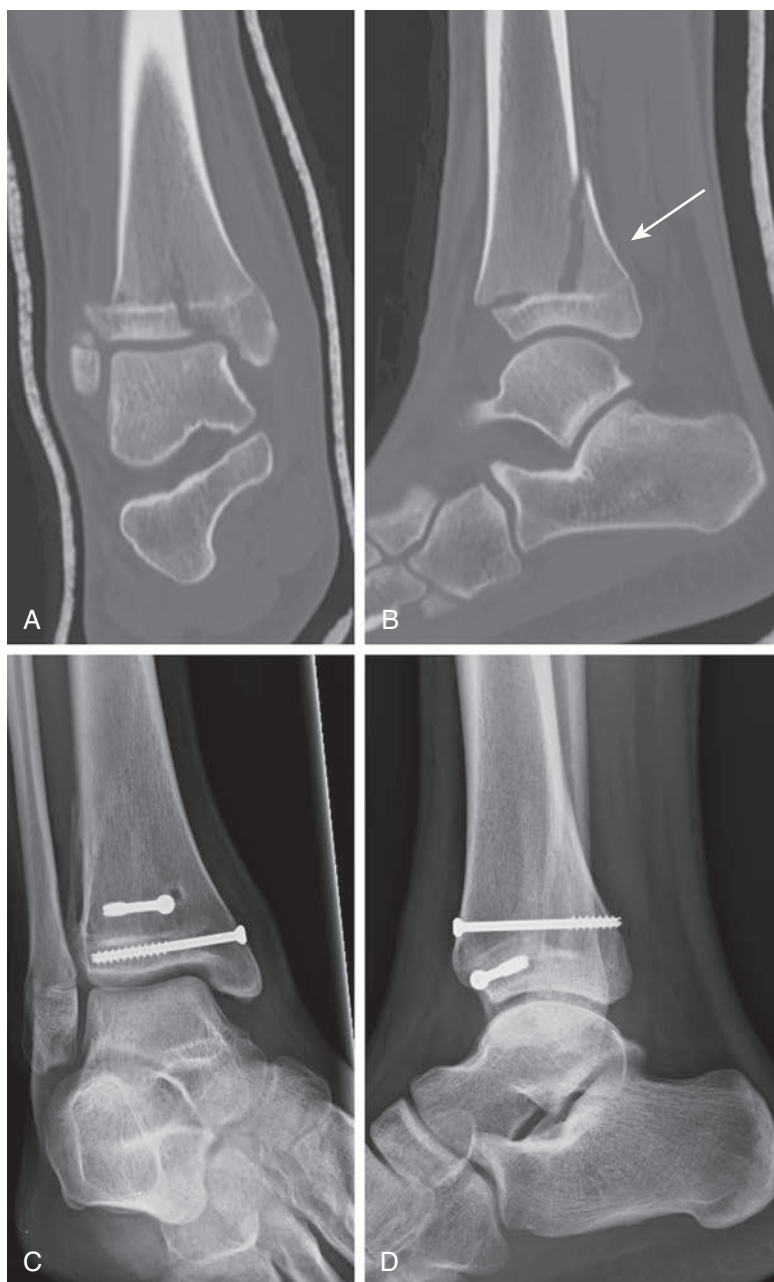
(A) Coronal and (B) sagittal CT of a 14-year-old boy who sustained a triplane fracture of the right ankle after falling off his bicycle. The unique shape of the triplane fracture's Thurstan-Holland fragment (white arrow) is discernable in the sagittal view. (C) Oblique and (D) lateral radiographs of the same patient 3 months later, after open reduction and internal fixation with two screws.
